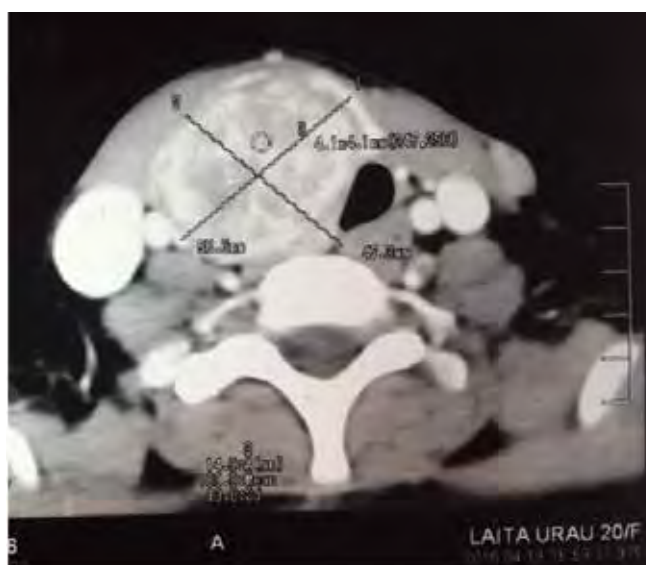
Fig I CT of thyroid with enlarged right lobe and absence left lobe
